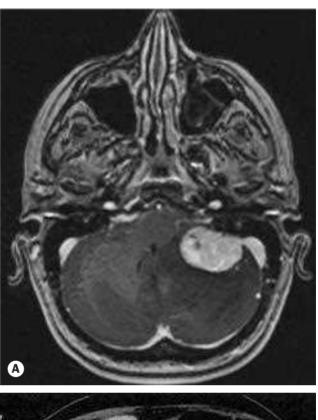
Tumours in von Hippel–Lindau syndrome. (A) Axial MRI showing a cerebellar haemangioma; (B) axial CT of the abdomen showing a renal carcinoma (*Courtesy of CD Forbes and WF Jackson, from* Atlas and Text of Clinical Medicine, *Mosby 2003 – fig. B*)
